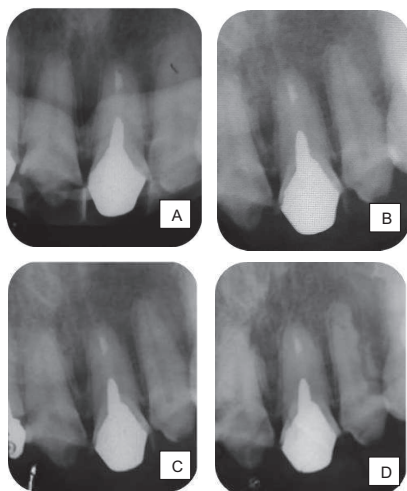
Periapical radiographic images showed the tissues healing. After the surgical procedures, there was no longer overfilled material and radiolucent area on periapical are began to disappear (A). Follow up evaluation showed tissues healing after 7 days (B), 1 month (C), and 3 months (D), marked by the disappearance of the radiolucent area on periapical.
